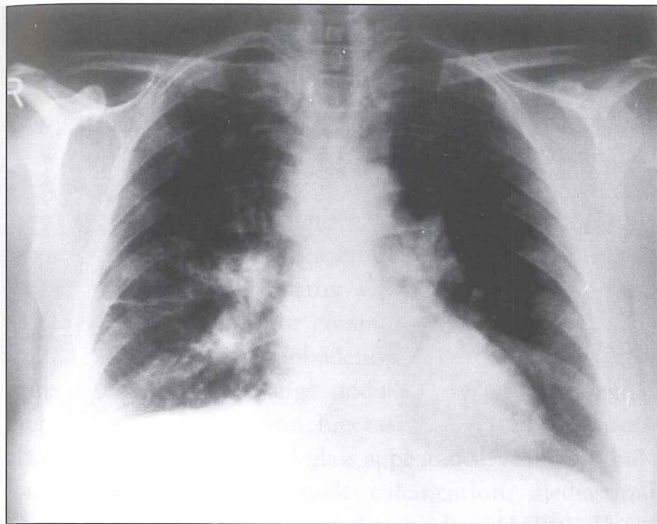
Chest X-ray at admission showing right-sided pleural effusion and bilaterally hilar enlargement.
